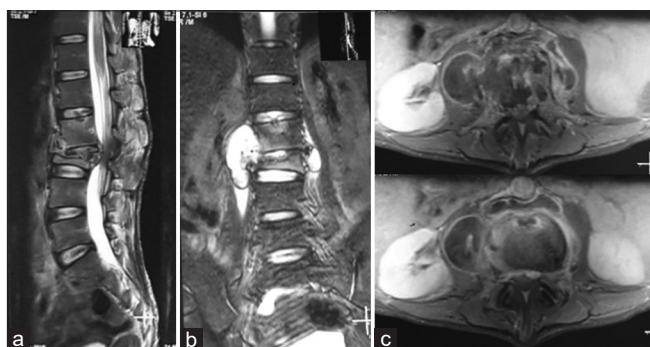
Kyphosis deformity due to destruction of lumbar III; (a) T2-weighted sagittal plane showed lytic lesion of lumbar III vertebral body and intervertebral body destruction with abscess formation extend to spinal canal causing severe thecal sac compression; (b) T2-weighted axial plane with contrast showed abscess in psoas muscle and rim enhancement
